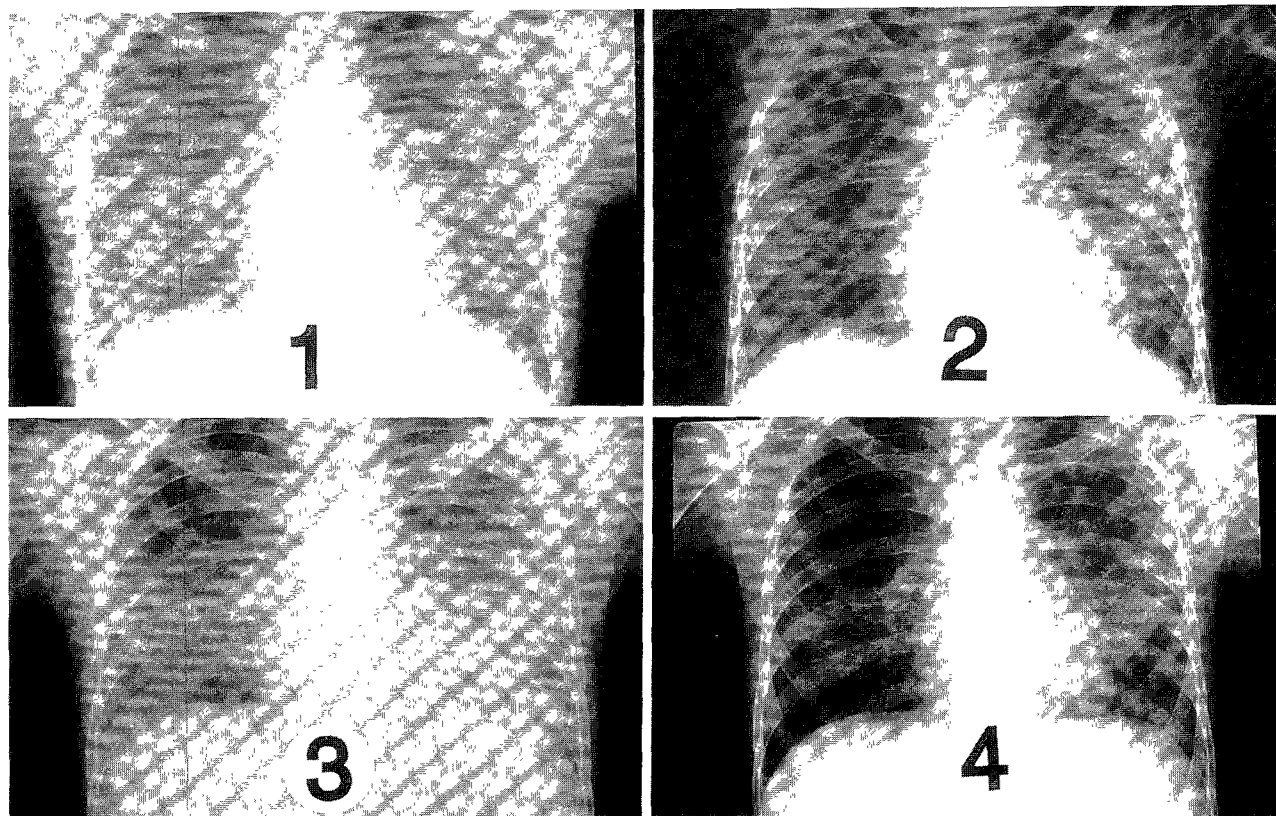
Chest X-ray finding of case 2. (1): Bilateral ground-glass opacity on admission. (2): Improved finding with 3 days of solu-cortef & dexamethasone. (3): Worsened 3 days later from stopping. (4): Improved again after resuming steroid for 2 days.
